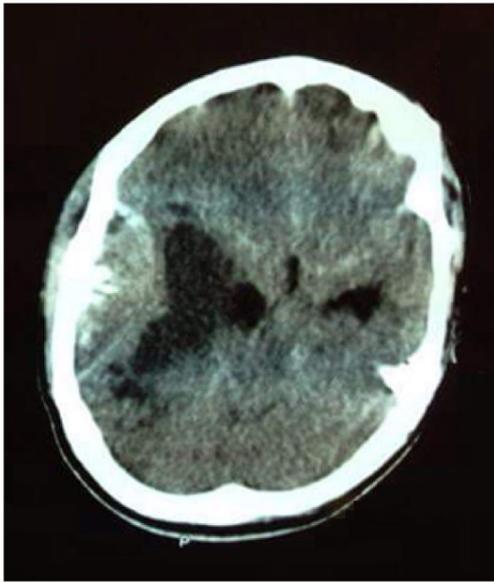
Axial CT scan of the brain showing a large, well-defined lesion in the right temporoparietal region involving the squamous part of temporal bone, suggesting a meningioma. Significant mass effect and midline shift are also seen
